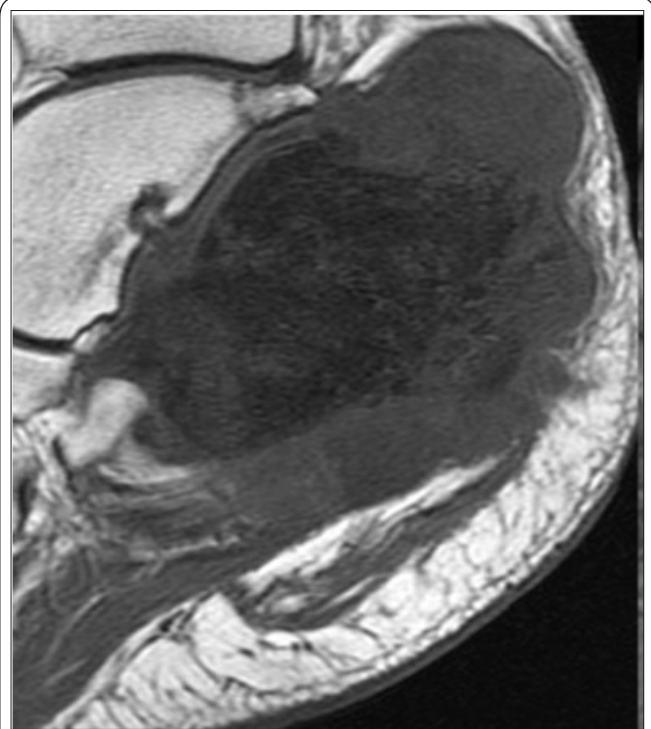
Sagittal T1 MRI showed the replacement of fatty marrow of the calcaneus with an intermediate signal rind.
